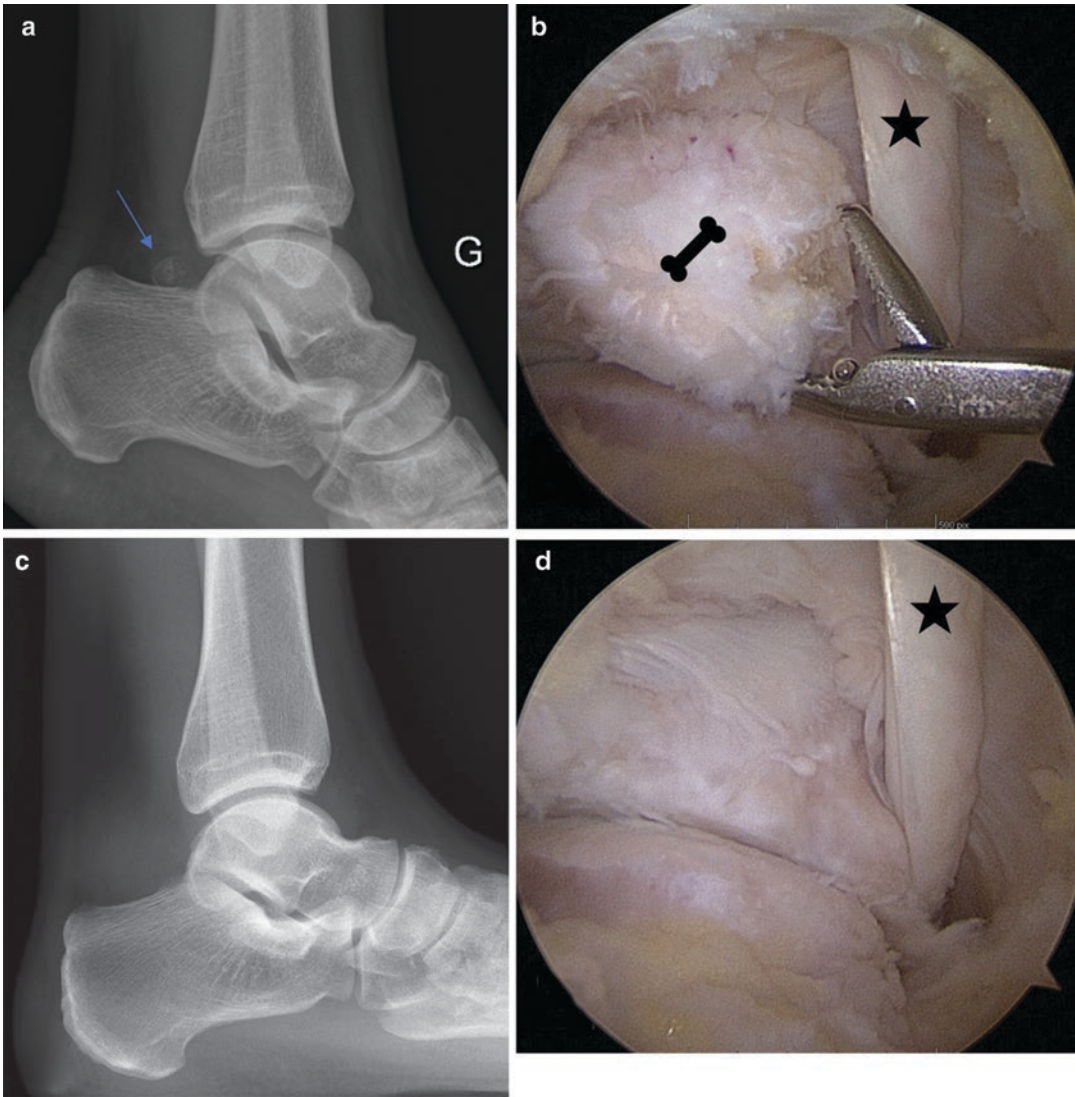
Os trigonum: (a) lateral ankle X-ray with os trigonum (blue arrow); (b) posterior ankle arthroscopic view of os trigonum (bone) and flexor hallucis longus
